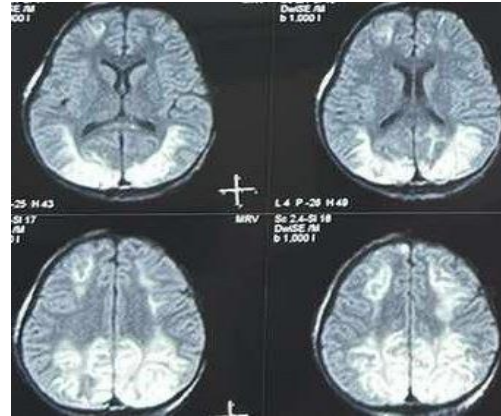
MRI DWI axial cuts taken on 4th post admission day showing laminar pattern of diffusion restriction in bilateral parietal and occipital region suggestive of acute laminar necrosis
